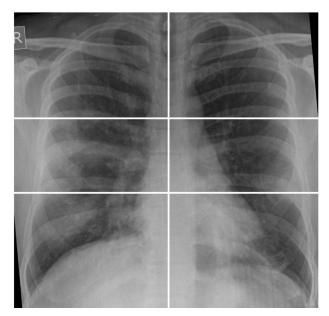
38 years male with COVID-19 disease shows areas of ground glass opacity in the peripheral region involving the bilateral lungs, predominantly in the middle and lower zones. Modified Chest X-ray severity scoring: (Upper zones R-L; Middle zones R-L; Lower zones R-L): 0-0, 2-1, 2-1 (Total score 6; Moderate severity).
